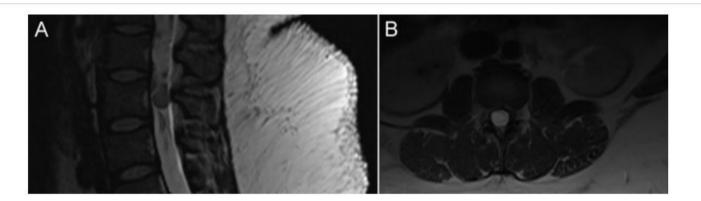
Contrasted lumbar spine MRI
